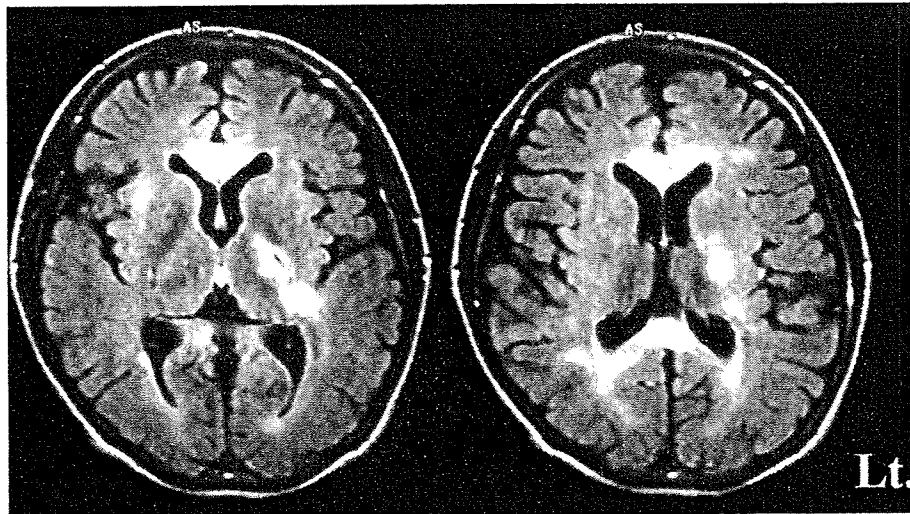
Brain MRI (fluid attenuated inversion recovery images) at age 21 revealed several T2 hyperintense lesions in her corpus callosum (genu, splenium), left internal capsule, and left corona radiata.
